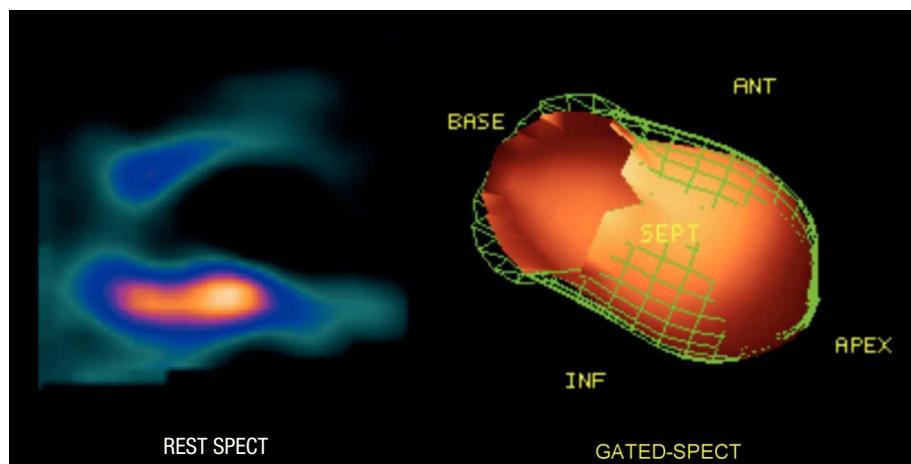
Left: divergent left ventricular pattern (transversal diameter at the apical level > transversal diameter at the basal level in vertical long-axis view) and absence of anteroapical uptake in myocardial perfusion SPECT at rest in a patient with anterior infarction. These criteria are highly specific for myocardial nonviability. Right: gated-SPECT of the same patient in whom anterior akinesia and septal and apical dyskinesia can be observed. End-diastolic volume, 248 mL; end-systolic volume, 203 mL; ejection fraction, 18%. Ant indicates anterior; Inf, inferior; SPECT, Single-Photon Emission Computed Tomography.
